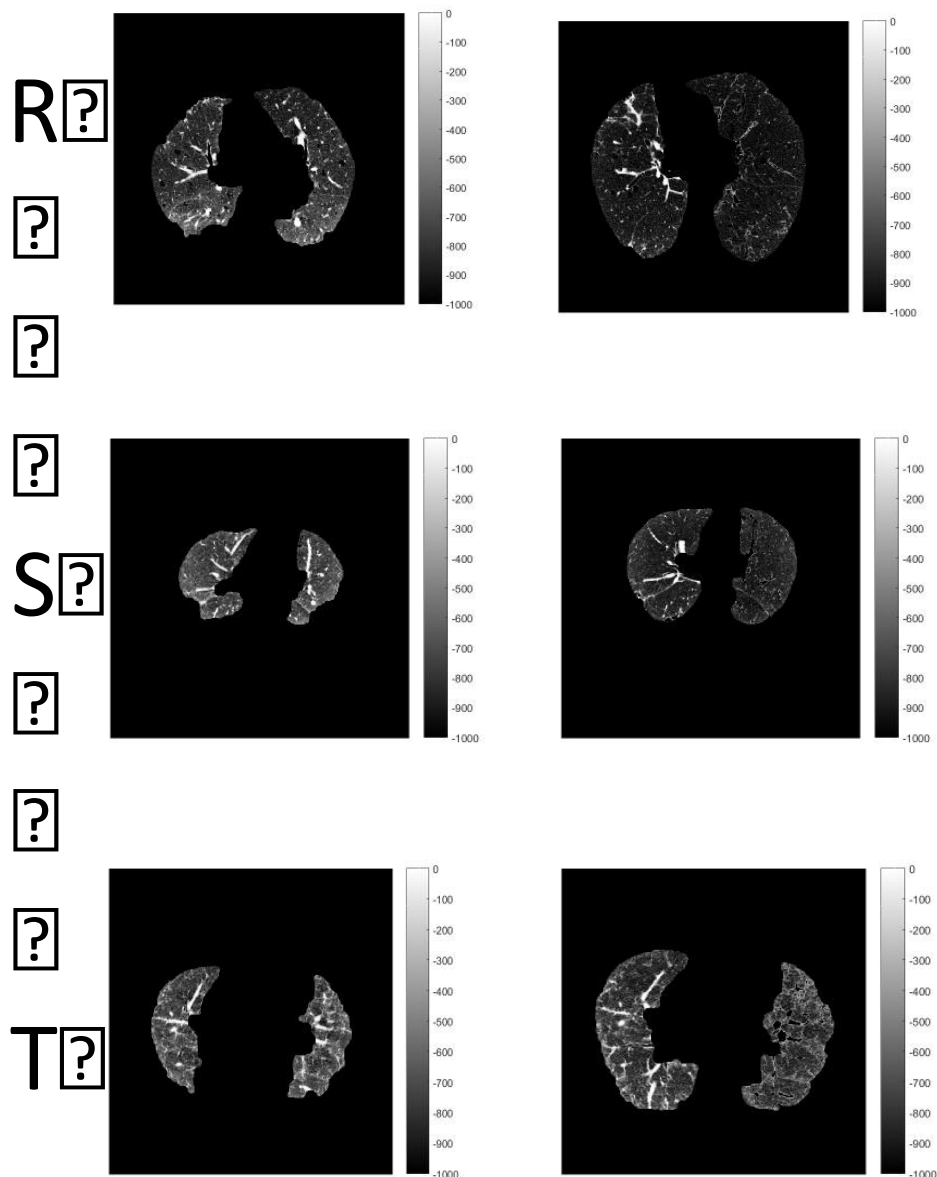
CT scans where only the anterior part of the scan showed sufficiently accurate segmentation to be used in analysis (scan pairs R to X)
